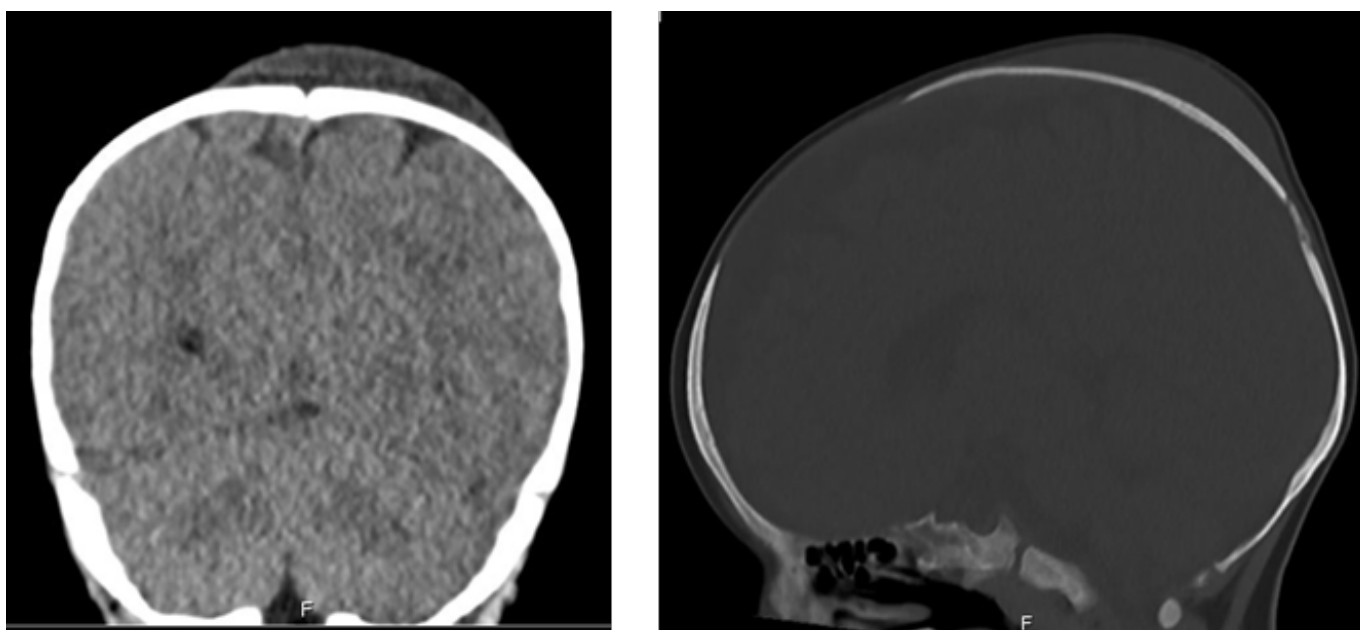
Cranial CT scan in the coronal (left) and sagittal (right, bone window) planes showing the presence of a subaponeurotic fluid collection freely crossing the sagittal suture without evidence of skull fracture or intracranial abnormality
